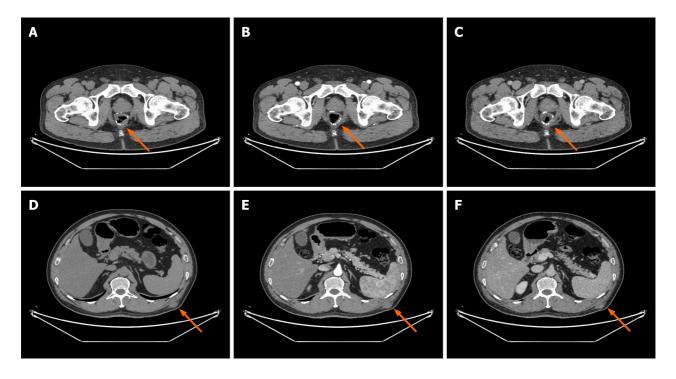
Contrast-enhanced abdominal computed tomography. A: Rectal anastomosis plain scan; B: Rectal anastomosis arterial phase scan; C: Rectal anastomosis venous phase scan; D: Plain scan of the soft tissue mass of the left waist; E: Arterial phase scan of the soft tissue mass of the left waist; F: Venous phase scan of the soft tissue mass of the left waist.
